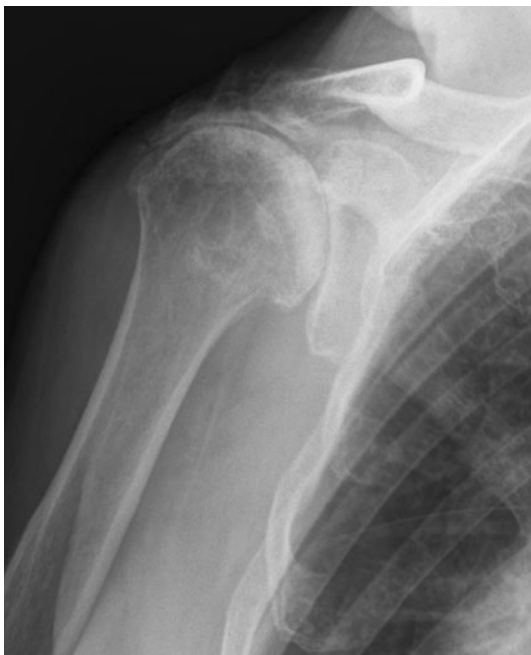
Compromise of the posterosuperior rotator cuff results in static superior subluxation that is apparent on the anteroposterior radiograph. (This figure was published in Gartsman GM, Edwards TB. *Shoulder Arthroplasty*. Philadelphia, PA: ©Saunders; 2008:219–221.)
